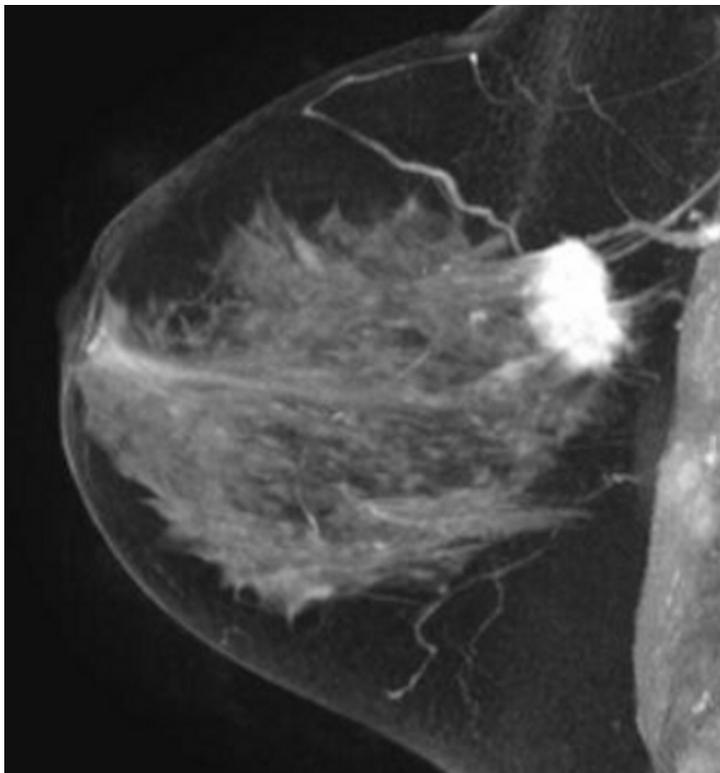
Sagittal image through the breast using a pathology sensitive MRI technique: source: Lodestone patient care. [ Ref 3]
